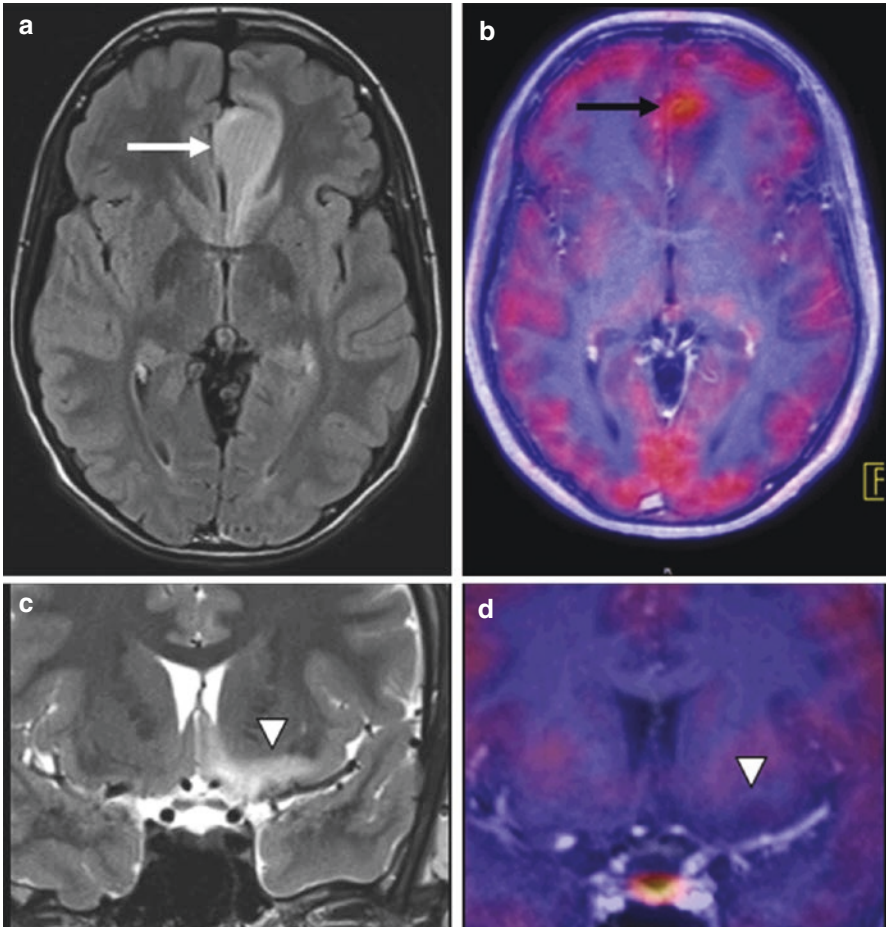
MET-PET/MR imaging in a 15-year-old boy with a non-enhancing multifocal primary brain tumor. The FLAIR MR image (a) shows signal hyperintensity in the left frontal lobe adjacent to the falx (*white arrow*). The T2-weighted MR image (c) shows signal hyperintensity more inferiorly in the left frontal lobe (*arrow head*). The fused MET-PET/MR images show focal uptake in the left frontal lesion along the falx (b, *black arrow*) but not in the more inferior left frontal lobe (d). This focus of increase MET uptake was used to guide stereotactic biopsy and yielded anaplastic astrocytoma. *This figure is courtesy of Drs. Franz Wolfgang Hirsch and Regine Kluge from the University Hospital of Leipzig, Germany.* (a) FLAIR; (b) fused MET-PET/MRI post-contrast T1; (c) T2; (d) fused MET-PET/MRI post-contrast T1
